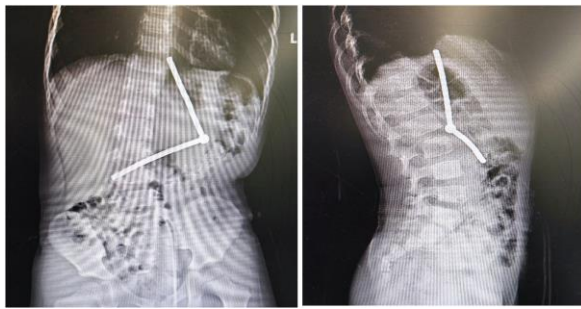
An abdominal X-ray showing the foreign body
